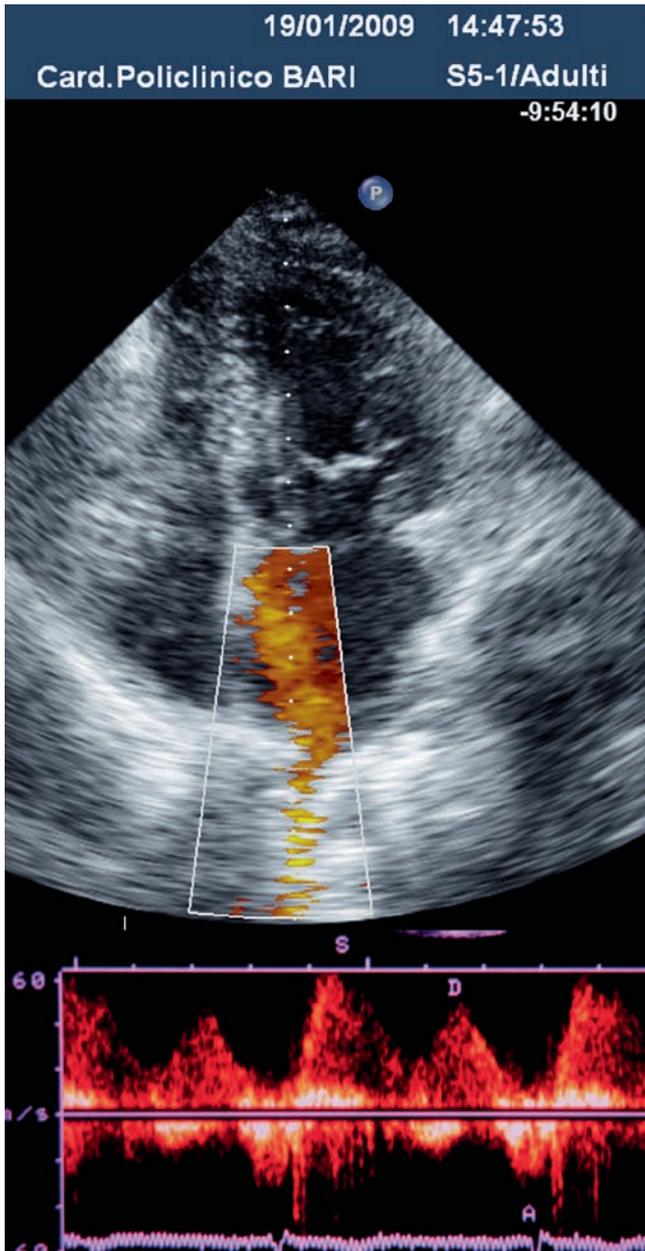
Normal pulmonary venous flow calculated by positioning the PW Doppler sample of volume of 1.5 cm into the lumen of the right upper pulmonary vein (*upper panel*) with a pulmonary venous flow systolic wave (s) higher than the diastolic one (d), and a small amount of atrial reversal flow (A)
